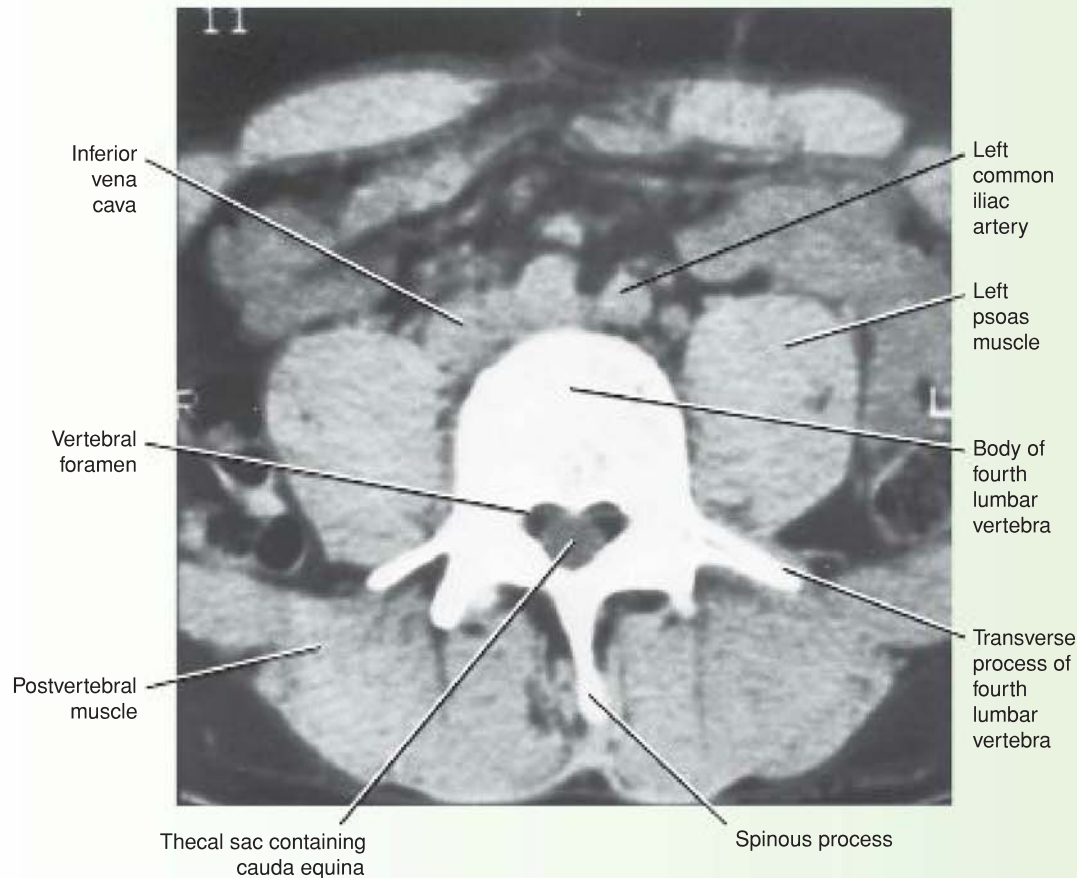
Horizontal (axial) CT scan of the fourth lumbar vertebra.
